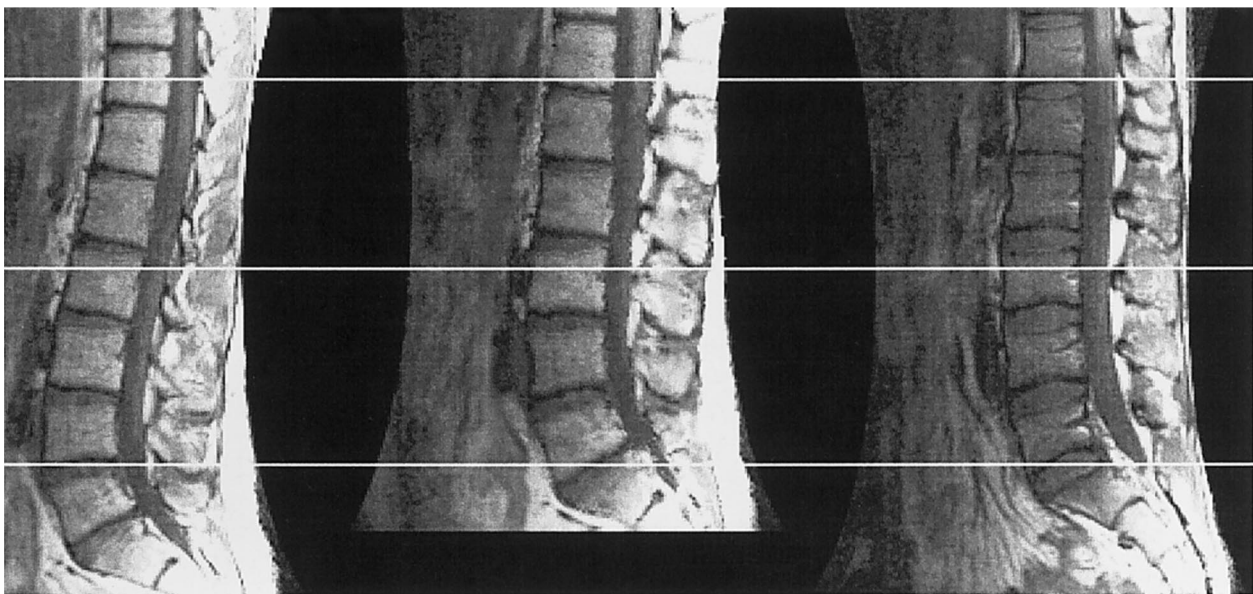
Comparative images of the spine. Three horizontal lines are drawn as a reference for comparisons of different levels of the spine. Left: representative section of a volumetric MR image of an individual's spine. Right: a similar section from the template. Middle: image of a spine warped to the template.
